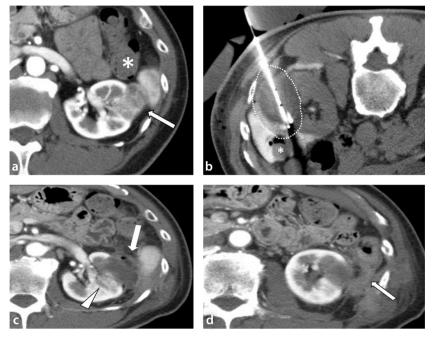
Cryoablation for a sporadic renal cell carcinoma of a 71-year-old man without preoperative lipiodol marking. (a) Contrast-enhanced CT showed an exophytic 2.9-cm mass at the anterolateral side of the left kidney (arrow). The mass and the descending colon (*) were in close contact. (b) CT-guided cryoablation was performed for the mass using cryoprobes with hydrodissection. However, part of the cryoablation area (dotted circle) extended over the colon (*). (c, d) Contrast-enhanced CT 1 month after cryoablation showed abscess formation (c, arrow) due to colon perforation (d, arrow), and part of the renal mass remained due to an insufficient cryoablation effect (c, arrowhead). Surgical resection was performed for the colon perforation, and additional cryoablation was performed for the residual lesions. CT, computed tomography.
